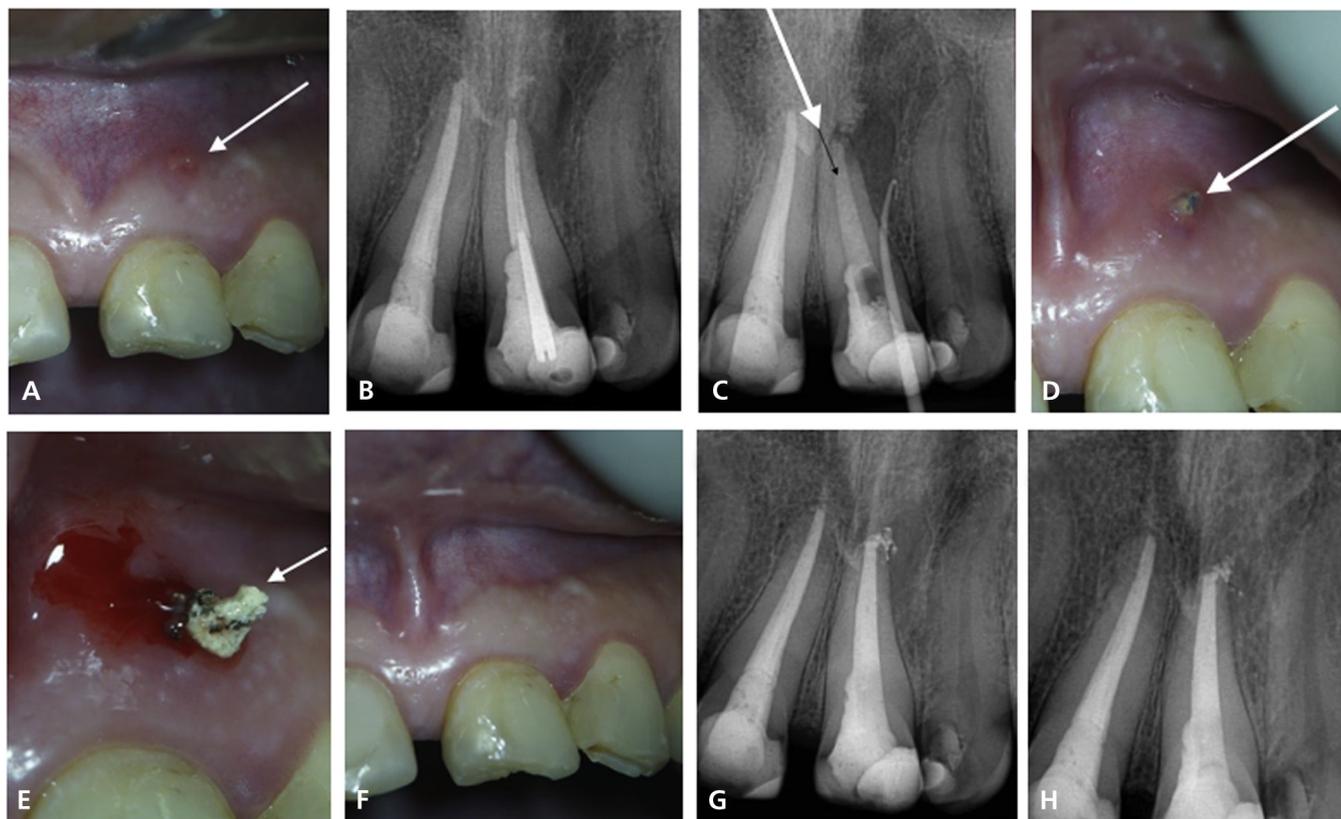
Case 1. A. Intraoral sinus tract (arrow) associated with tooth no. 9. B. Periapical radiograph revealed a J-shaped radiolucency surrounding the apex and radiopaque structures consistent with a post and previously treated root canal in tooth no. 9. C. No intracanal crack (arrows) was detected. After removal of the post and restoration material, the root canal was cleaned, shaped, and restored with Ultracal XS (Ultradent) paste. D. Hardened exogenous material (arrow) was observed in the sinus tract. E. Apical palpation provoked drainage of the material (arrow). F. Tissue repair. G. Periapical radiograph after root canal restoration. H. Follow-up at 8 months.
